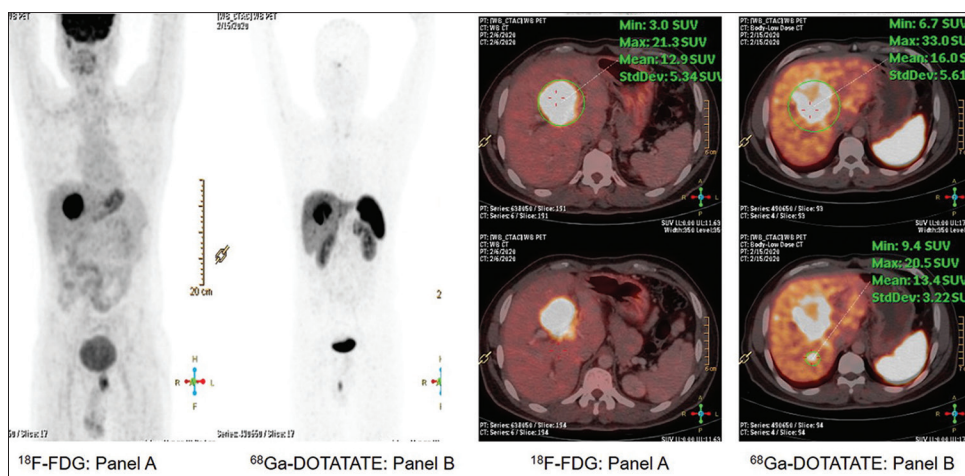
Dual tracer positron emission tomography and computed tomography scan (¹⁸F-fluorodeoxyglucose positron emission tomography and computed tomography and ⁶⁸Ga-DOTATATE positron emission tomography and computed tomography) showing both somatostatin receptor expressing and fluorodeoxyglucose avid hypodense liver lesions, largest in segment IVa and IVb measuring 6.6 × 5.0 cm with SUVmax (¹⁸F-fluorodeoxyglucose)-21.3 (panel A) and SUVmax (⁶⁸Ga-DOTATATE)-33 (panel B)
